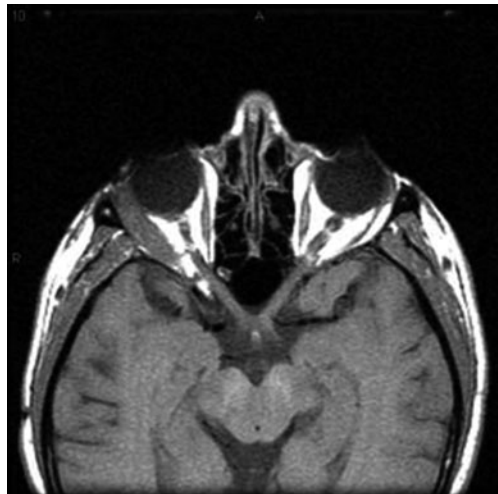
Magnetic resonance imaging of the orbit shows a metastasis to the right lateral rectus muscle from cutaneous melanoma
